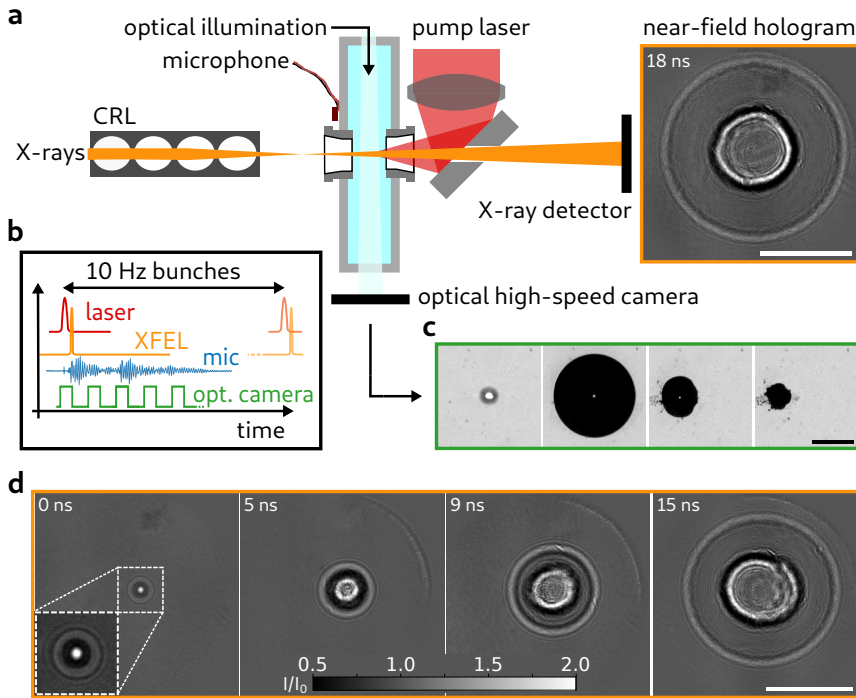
Holographic imaging of cavitation at the MID instrument. a, The FEL X-ray pulses are focused to nanometer spot size by the beryllium CRLs. A cuvette with water is placed behind the X-ray focus. The pump laser is focused by a lens and reflected by a subsequent plane mirror into the water to seed the bubble. The X-ray and the laser beam are antiparallel. The X-ray beam passes through a small hole in the laser mirror to the X-ray detector. The distance between X-ray focus and laser focus, i.e. the seeding point of cavitation, is $z_{01} = 144$ mm and between X-ray focus and detector $z_{02} = 9578$ mm. A high-speed optical camera observes the bubble formation perpendicular to the X-ray beam. A microphone at the cuvette's wall registers the acoustic signal of cavitation events. b, Timing scheme of the experiment. The pump laser excites a cavitation bubble at a time Δt prior to the FEL pulse. The optical high-speed camera acquires a series of images with the first frame synchronized to the pump laser pulse. The microphone signal of the acoustics is recorded (mic). c, Image sequence of the optical high-speed camera. The first frame (left) shows the plasma spark. The following frames have time delays of $40 \mu\text{s}$, $140 \mu\text{s}$ and $160 \mu\text{s}$ (left to right) with respect to the first frame. d, Empty-beam corrected X-ray holograms of cavitation events at different times Δt , indicated in the top left corner. The holograms show strong contrast at the inner interface (gas/shockwave) and at the outer interface (shockwave/equilibrium water). Scale bars: $50 \mu\text{m}$ (a, d), $500 \mu\text{m}$ (c).
